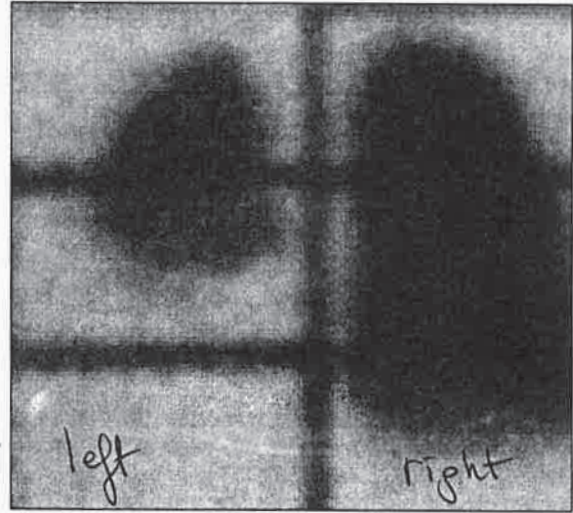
Quantitative analysis of lung perfusion scintigraphy showed 81% of lung perfusion provided by right and 19% by left lung.
